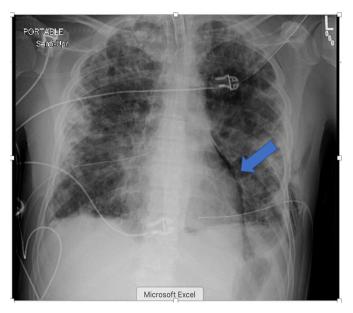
Chest X-ray with small volume pneumopericardium. Single arrow: Air within pericardial sac.
